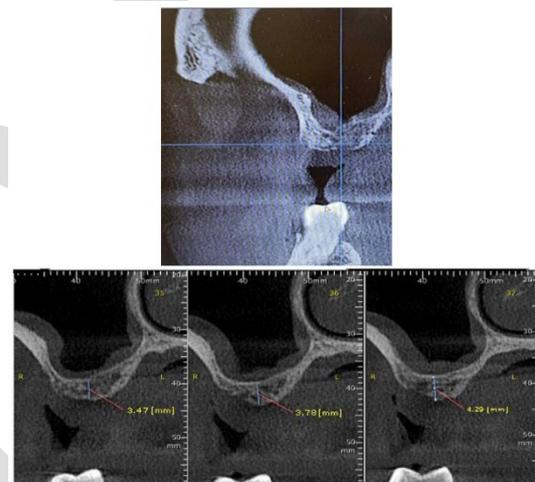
Six months post-operative computed tomography.
